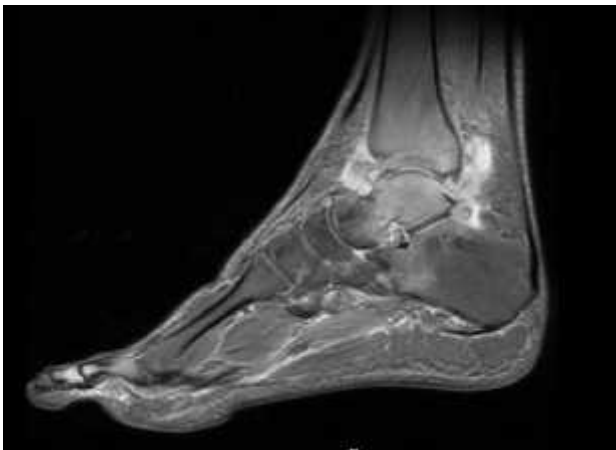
MRI of ankle showing diffuse synovial thickening around the ankle joint
